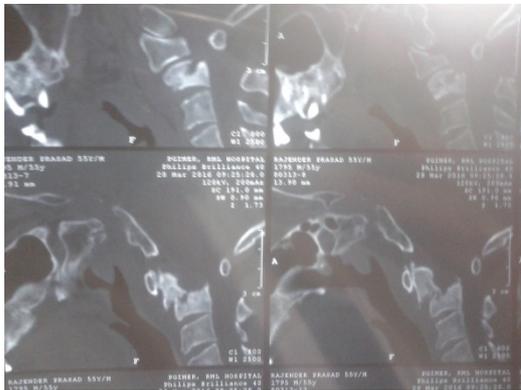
Sagittal CT images showing displaced odontoid # type 3
